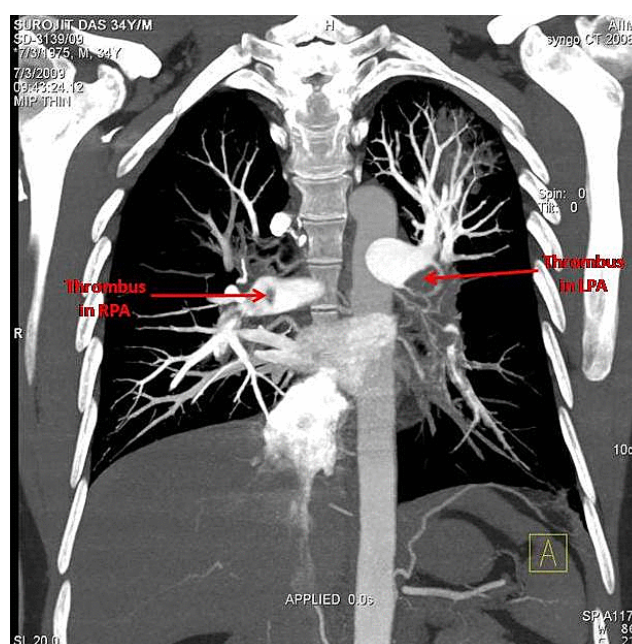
CT angiography showing filling defects representing thrombi in right and left pulmonary arteries extending into upper and lower segmental arteries.
